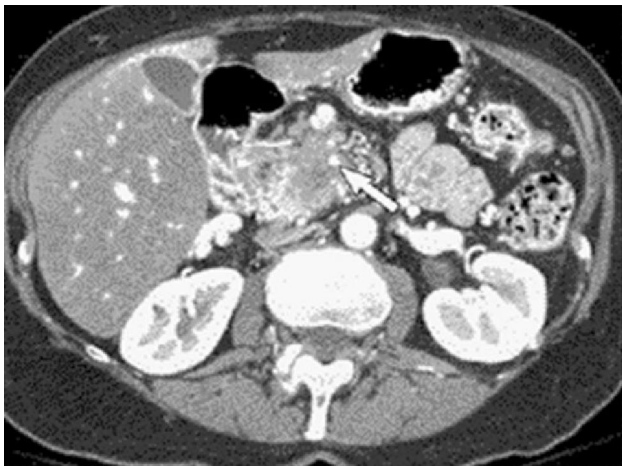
Axial post contrast CT section of Abdomen showing pancreatic head mass invading superior mesenteric artery.¹⁴
